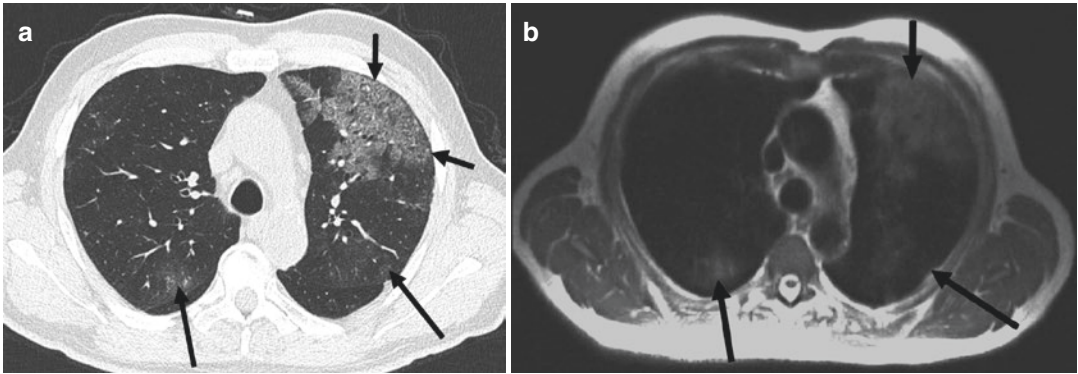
A 76-year-old patient with myelodysplasia suffering from *Pneumocystis jirovecii* pneumonia (With the permission of Springer: Eibel et al. 2006a). (a) Thin-section CT above the level of the carina. Ground-glass opacity is the predominant finding in the ventral portion of the left
